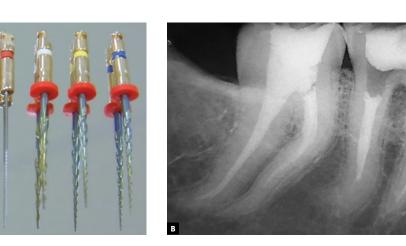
A) ProDesign S system. B) Final radiograph.
